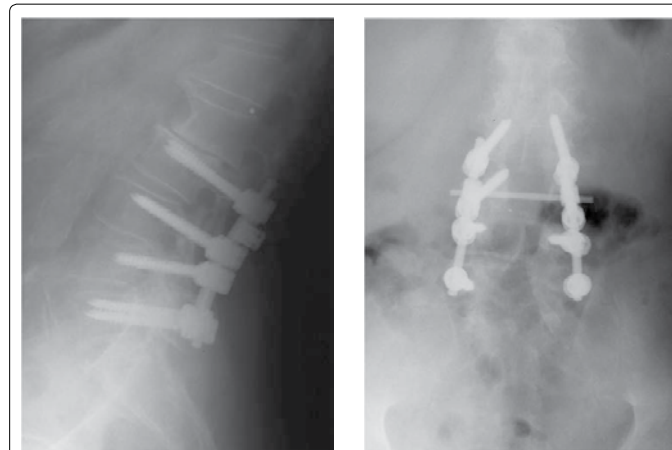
Preoperative Lateral (a) and A/P (b) x-rays of a 77 years old patient who suffered from low back pain and underwent a L3, L4, L5 laminectomy and a L2, L3, L4, L5 posterior fixation with screws, rigid rods, and cross-link. After 2 months free of symptoms, severe low back pain, L1 right radiculopathy, and partial cauda equina syndrome were presence.
